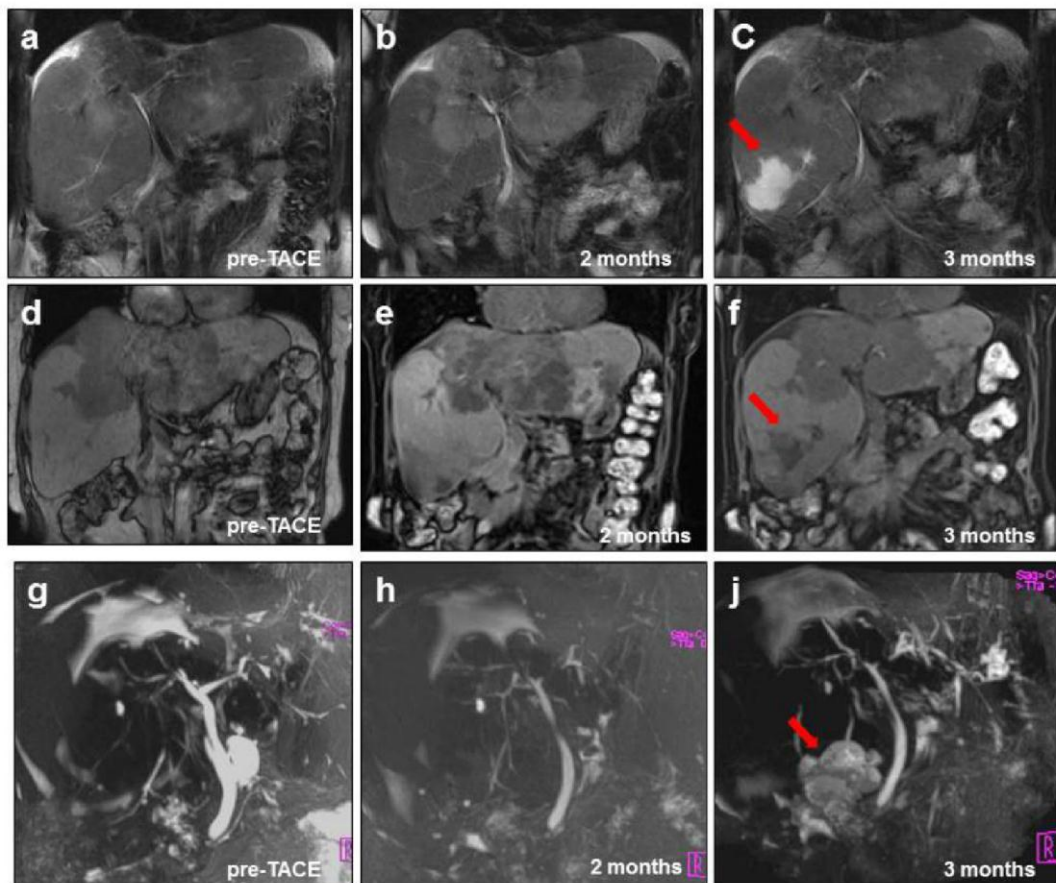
Delayed manifestations of biliary complications. MRI of 65 years old female patient underwent TACE for cholangiocarcinoma: pre-TACE T2-WI (a), T1-WI (d), MRCP (g); two months after TACE T2-WI (b), T1-WI (e) demonstrating moderate heterogeneity of the six liver segment parenchyma only, MRCP (h); three months after TACE T2-WI (c), T1-WI (f) and MRCP (j) show postnecrotic bile duct cyst (arrow).
